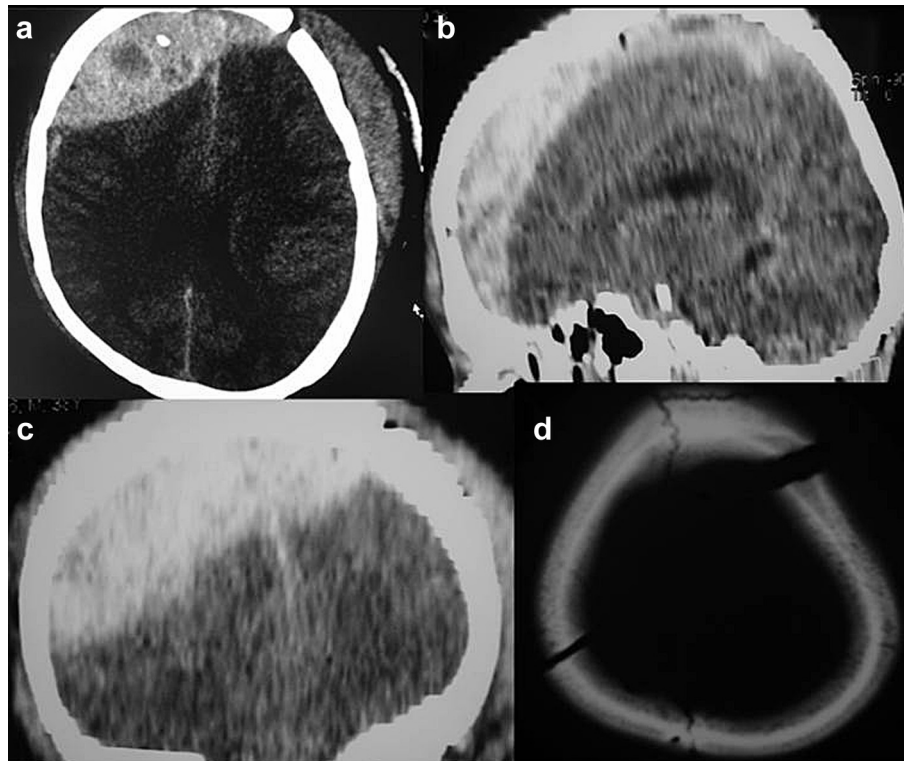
Non-contrast computed tomography of head shows the EDH in axial, sagittal, coronal cuts and the fracture of left frontal and right parietal bone in bone window (a, b, c and d).
